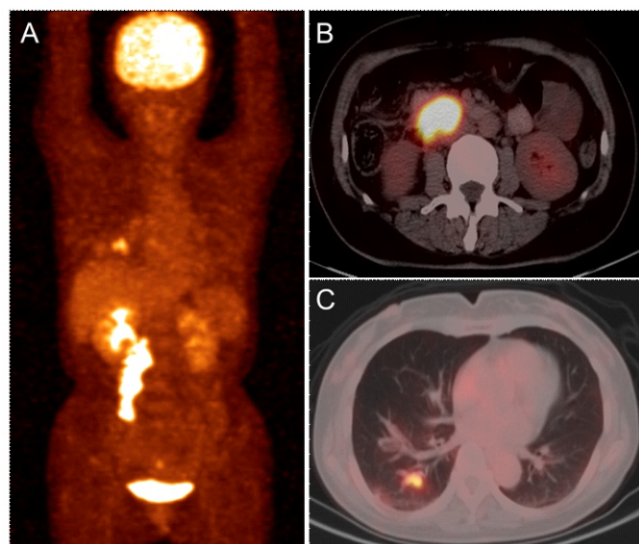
Fluorine-18-FDG PET/CT imaging of primary tumor and tumor embolism. (A) MIP image with RPLS and IVC tumor thromboembolism (arrowhead), pulmonary tumor thromboembolism (short arrow) and hydronephrosis of the right kidney and right ureter (long arrow); (B) RPLS and IVC tumor thromboembolism (arrowhead); (C) pulmonary tumor thromboembolism (short arrow).
